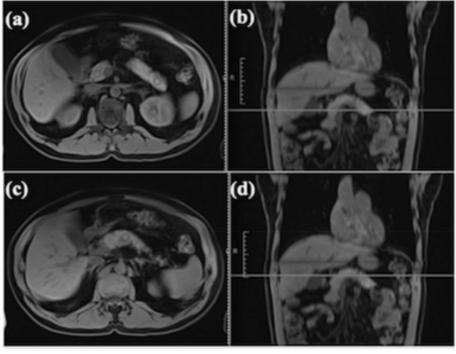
Selection of positioning of the circular regions of interest in the pancreas head, body, and tall to quantify IPLs. (a) Circular regions of interest of 1 cm² drawn on the head and tail of the pancreas on an axial abdominal MRI image. (b) Coronal MRI image, with the horizontal line depicting the position of the axial image (a). (c) Circular region of interest of 1 cm2 drawn on the body of the pancreas on an axial abdominal MRI image. (d) Coronal MRI image with the horizontal line depicting the position of the axial image (c).
